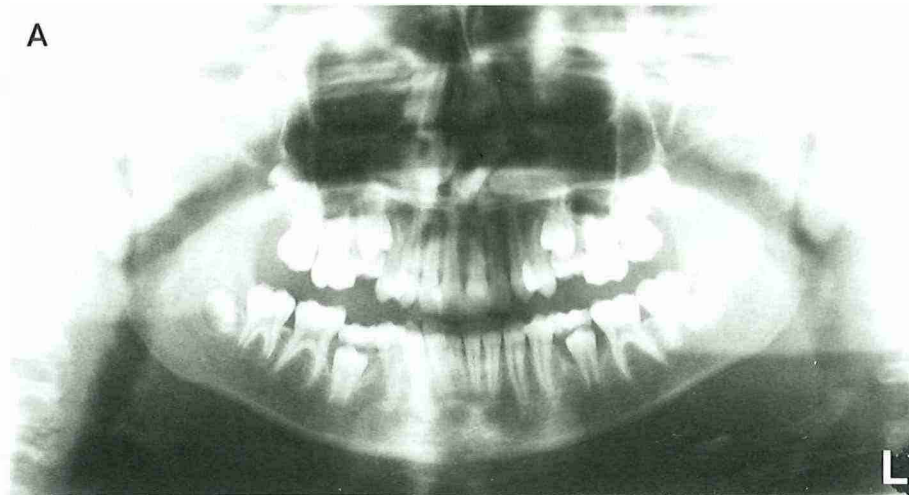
A Orthopantomogram of a 12-year-old girl showing secondary retention of the maxillary second deciduous molars and mandibular right second deciduous molar. B Orthopantomogram of the same patient after 11 months without any active treatment. The premolars have erupted normally and the alveolar process had recovered its height.
